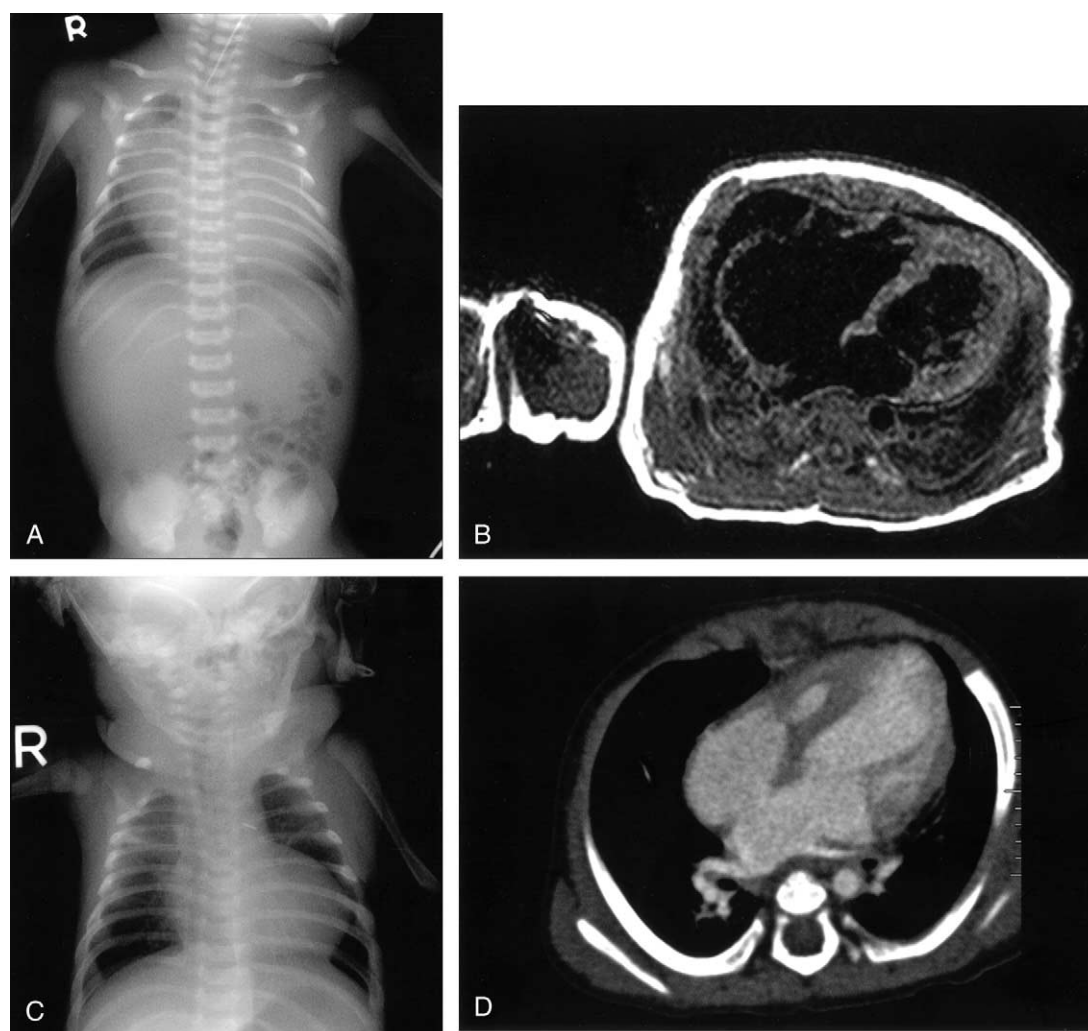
Preoperative chest x-ray (A) and cardiac magnetic resonance image (B) showing severe cardiomegaly with a huge right atrium and atrialized right ventricle. Postoperative chest radiograph (C) and cardiac computed tomogram (D) at 6 months postoperatively showing decreased heart size and an effectively obliterated atrialized right ventricle.
